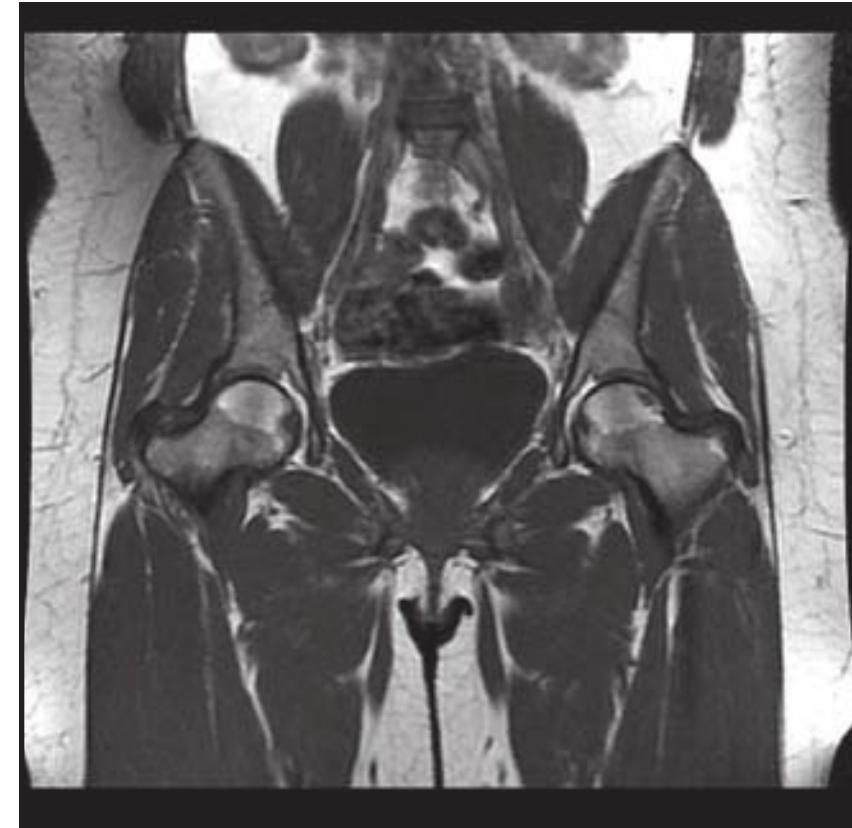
Magnetic resonance image of hip osteonecrosis.
